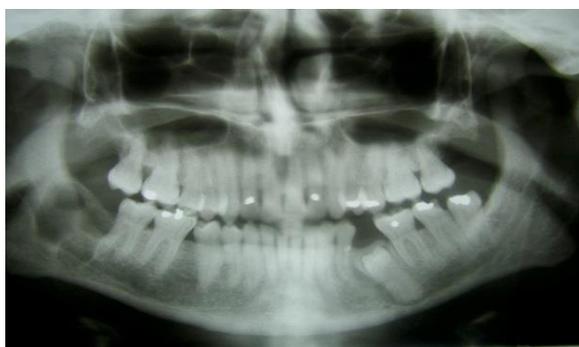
Orthopantomogram (11/2009) showing well defined radiolucency associated with impacted right lower third molar.
